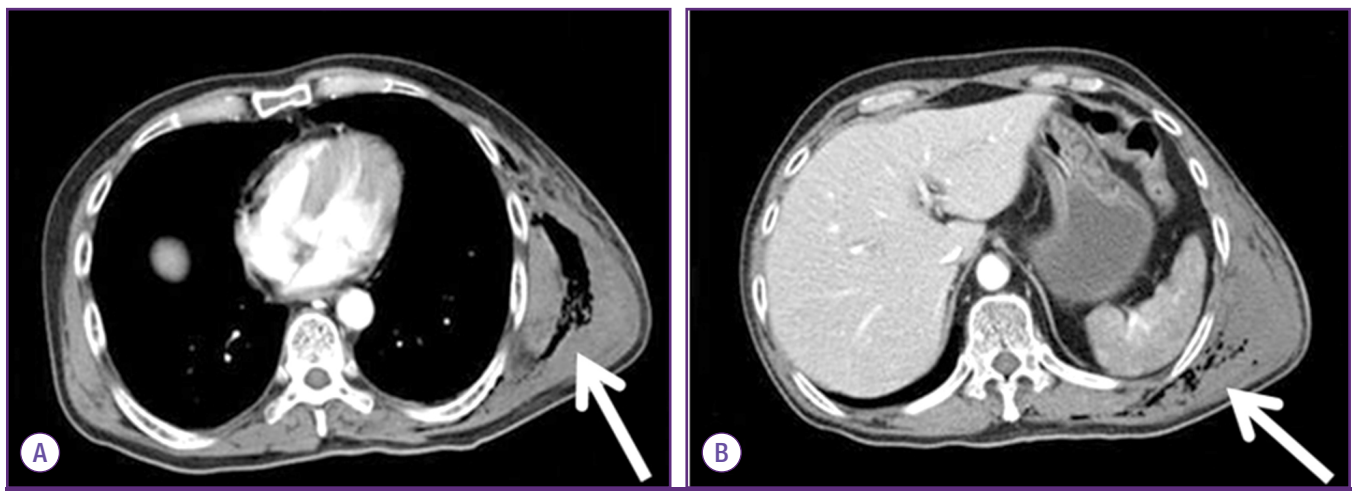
Computed tomography of chest and abdomen. Subcutaneous emphysema on (A) the left chest wall (arrow) and (B) left trunk (arrow).
